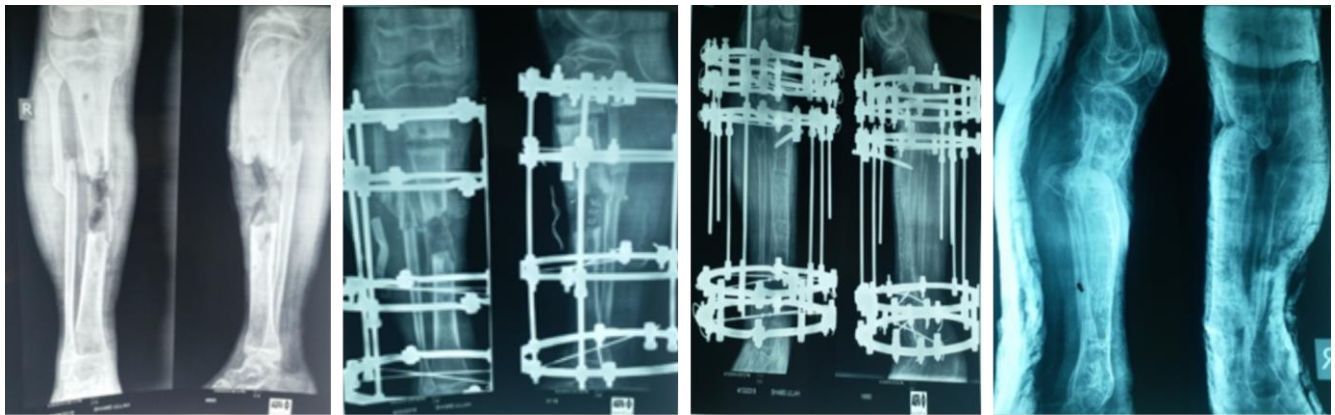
Fig IIIA: Infected gap non union tibia. Fig IIIB: Ilizarov applied. Fig IIIC: Follow up Xray. Fig IIID: Xray after Ilizarov removal and fracture union.
